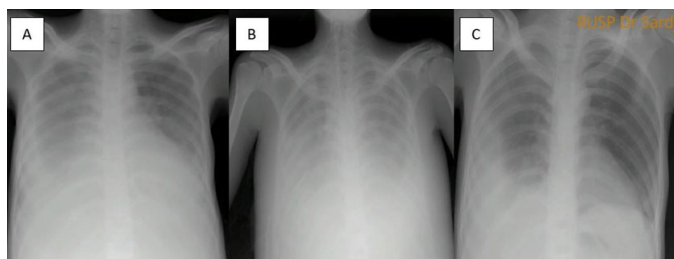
(A) Thorax X-ray before chemotherapy (July 15, 2018). (B) After first cycle chemotherapy (July 26, 2018). (C) After second cycle chemotherapy (Aug 20, 2018).
